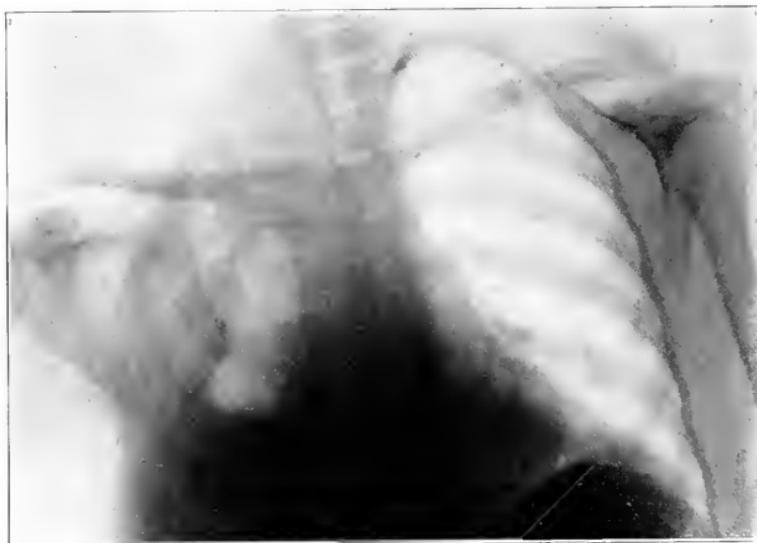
Roentgenogram taken one week after operation showing partial correction of deformity; the clear area on the left side of the chest is the site of removal of thickened parietal pleura.
